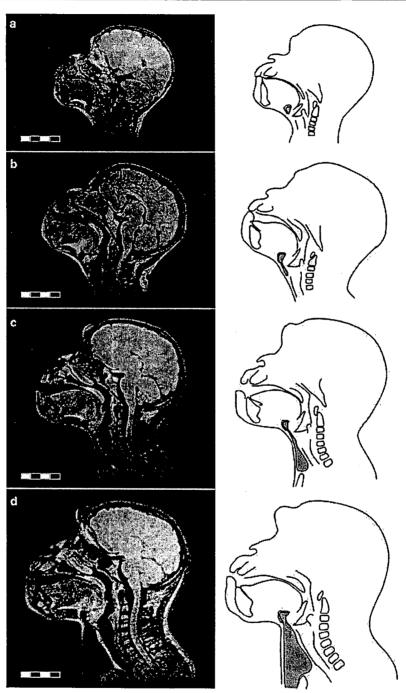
MR images of the laryngeal air sac for the same female chimpanzee (Pal). (a) At 4 mo, a small pouch had formed in the dorsal area of the hyoid bone. (b) At 18 mo, the sac occupied the entire area dorsal to the hyoid bone and inferior to the ventral aspect of the laryngeal cartilages. (c) At 24 mo, the sac had expanded to reach the sternum. (d) At 48 mo, the sac had expanded inferiorly into the ventral aspect of the pectoral regions and had widened at the level of the trachea. Scale in cm.
